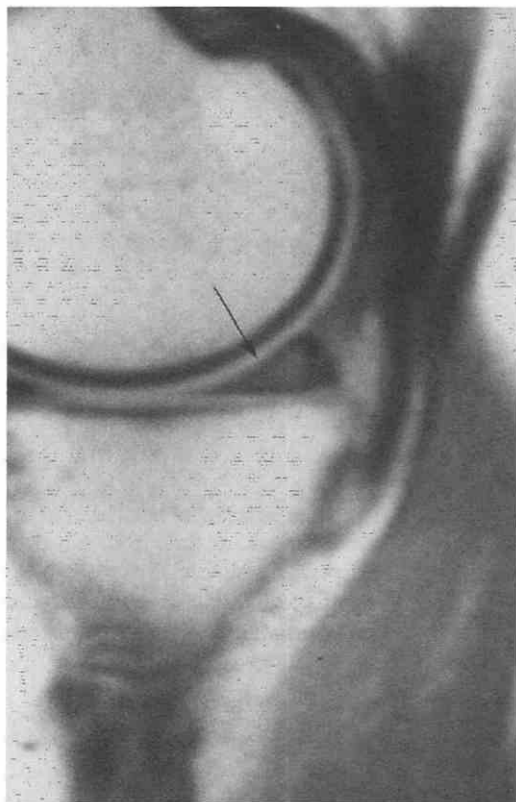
Meniscus-within-a-meniscus appearance. Sagittal T1-weighted image shows increased signal intensity throughout the confines of the posterior horn of the medial meniscus. Although signal does not extend to the articular surface, a true tear is seen at arthroscopy 50% of the time.
